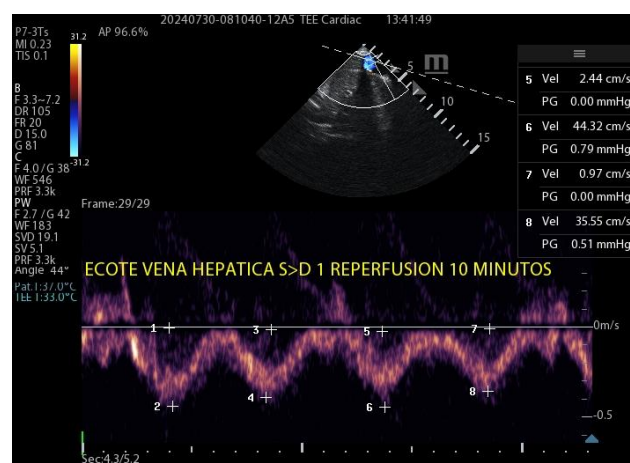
Hepatic Vein Doppler at 10th minute reperfusion in the kidney transplant patient.
